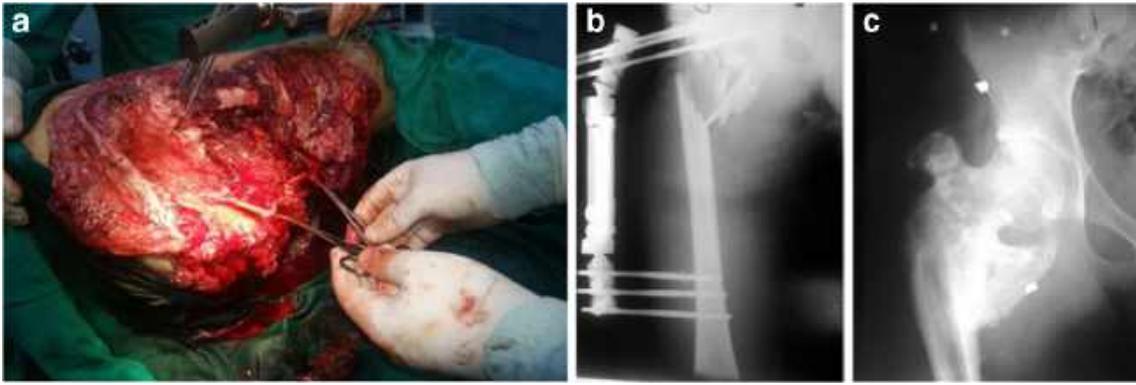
a Intra-operative photograph taken during application of the external fixator for an open femur fracture with extensive soft tissue injury. b Post-operative anteroposterior radiograph of the right femur following
